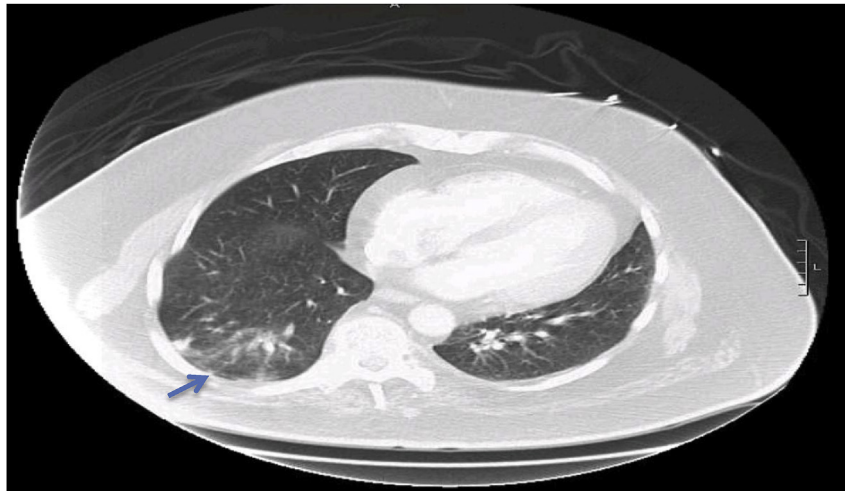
CT chest with IV contrast taken at presentation of massive hemoptysis showing right lower lobe infiltrate.
